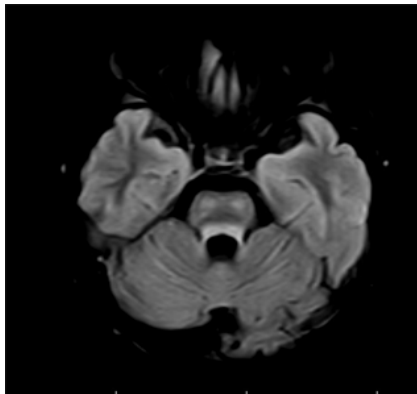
MRI showing, Axial FLAIR demonstrating central pontine hyperintensity with relative sparing of corticospinal tracts - Trident sign.
